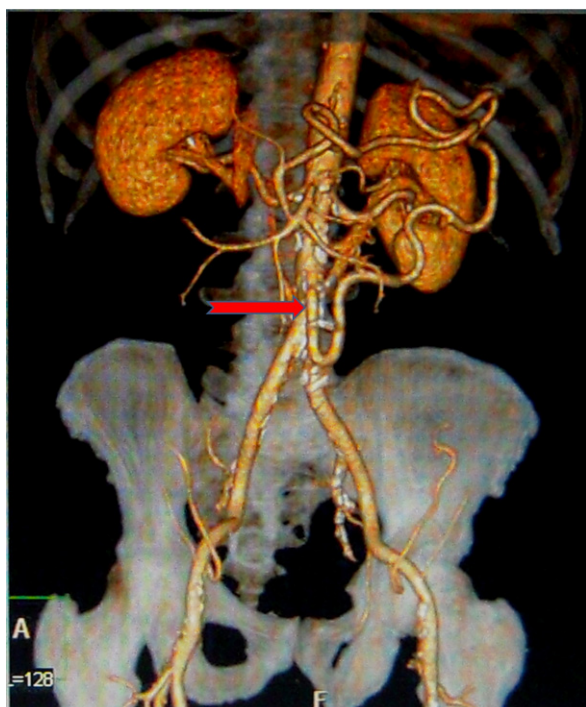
Three-year CT scan demonstrating the good patency of the graft (*arrow*) and the presence of a good Riolo arcade.
